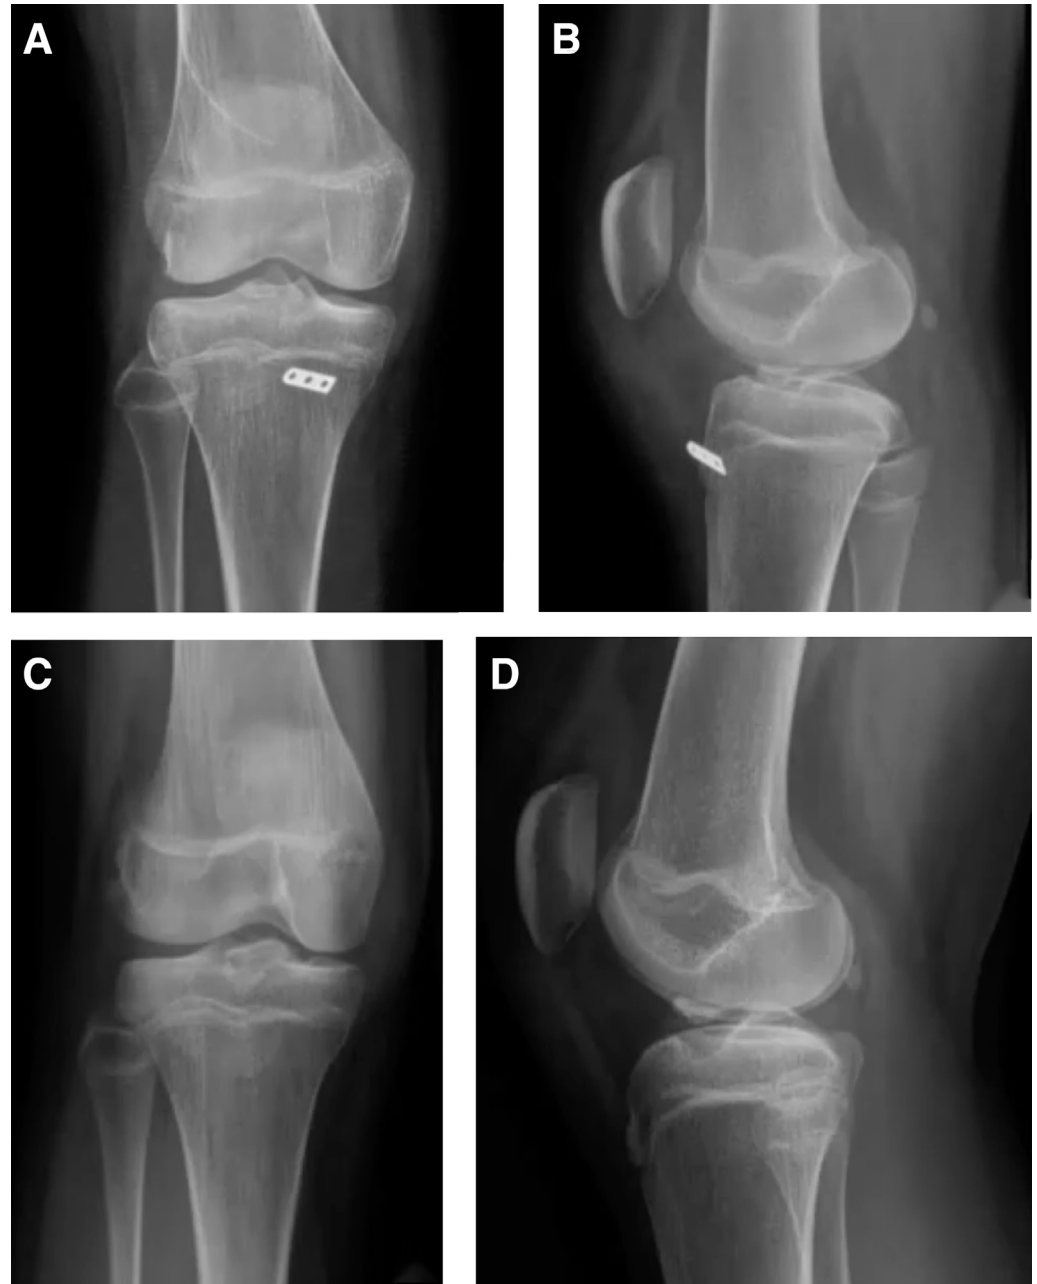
Postoperative radiographic imaging: (A) anteroposterior view of right knee, (B) lateral view. Initial radiographic imaging: (C) anteroposterior view of right knee, (D) lateral view.
